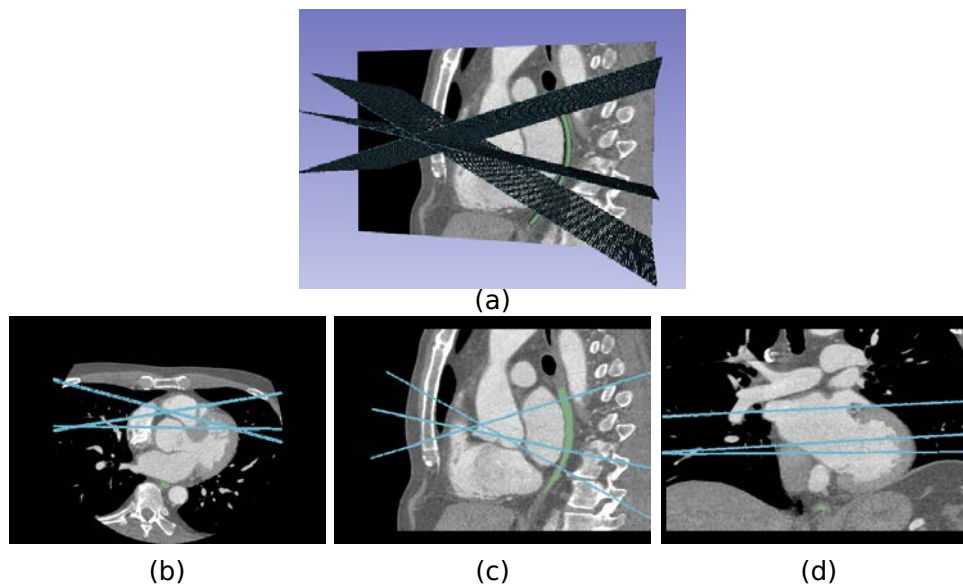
3D visualization of the position of the US slices estimated by our method inside the preoperative CT acquisition.
